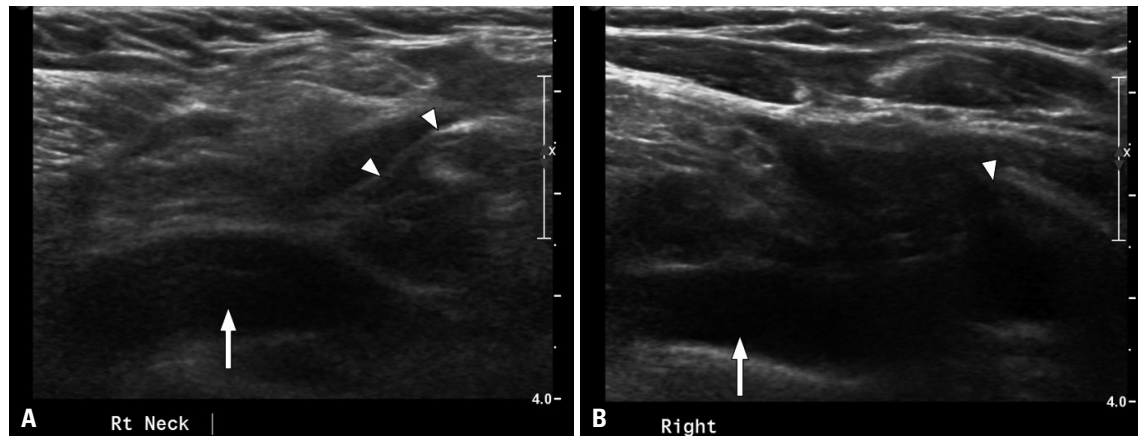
One month and 8 month follow-up ultrasonographic images of the right supraclavicular fossa revealed complete shrinkage and non-visualization of the cervical lymphatic malformation which was located adjacent to the scalene muscles (arrowheads) and the right subclavian vein (arrows). (A) One month follow-up. (B) Eight month follow-up.
